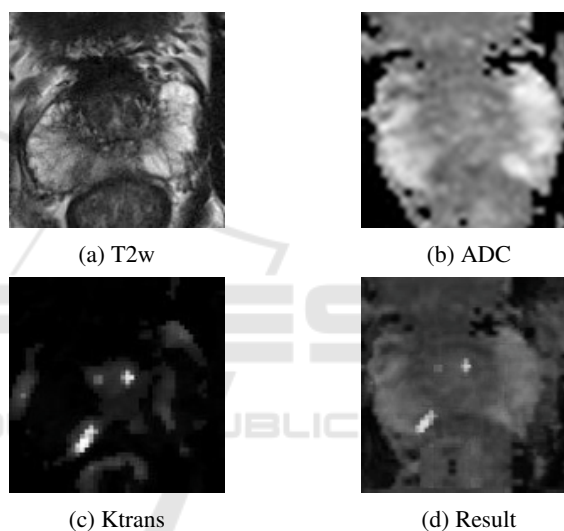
mp-MRI used images.
